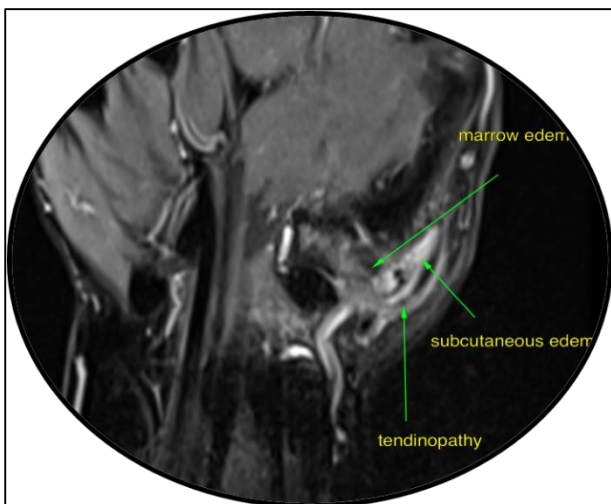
MRI showing tenosynovitis of the 1st dorsal compartment tendons.
